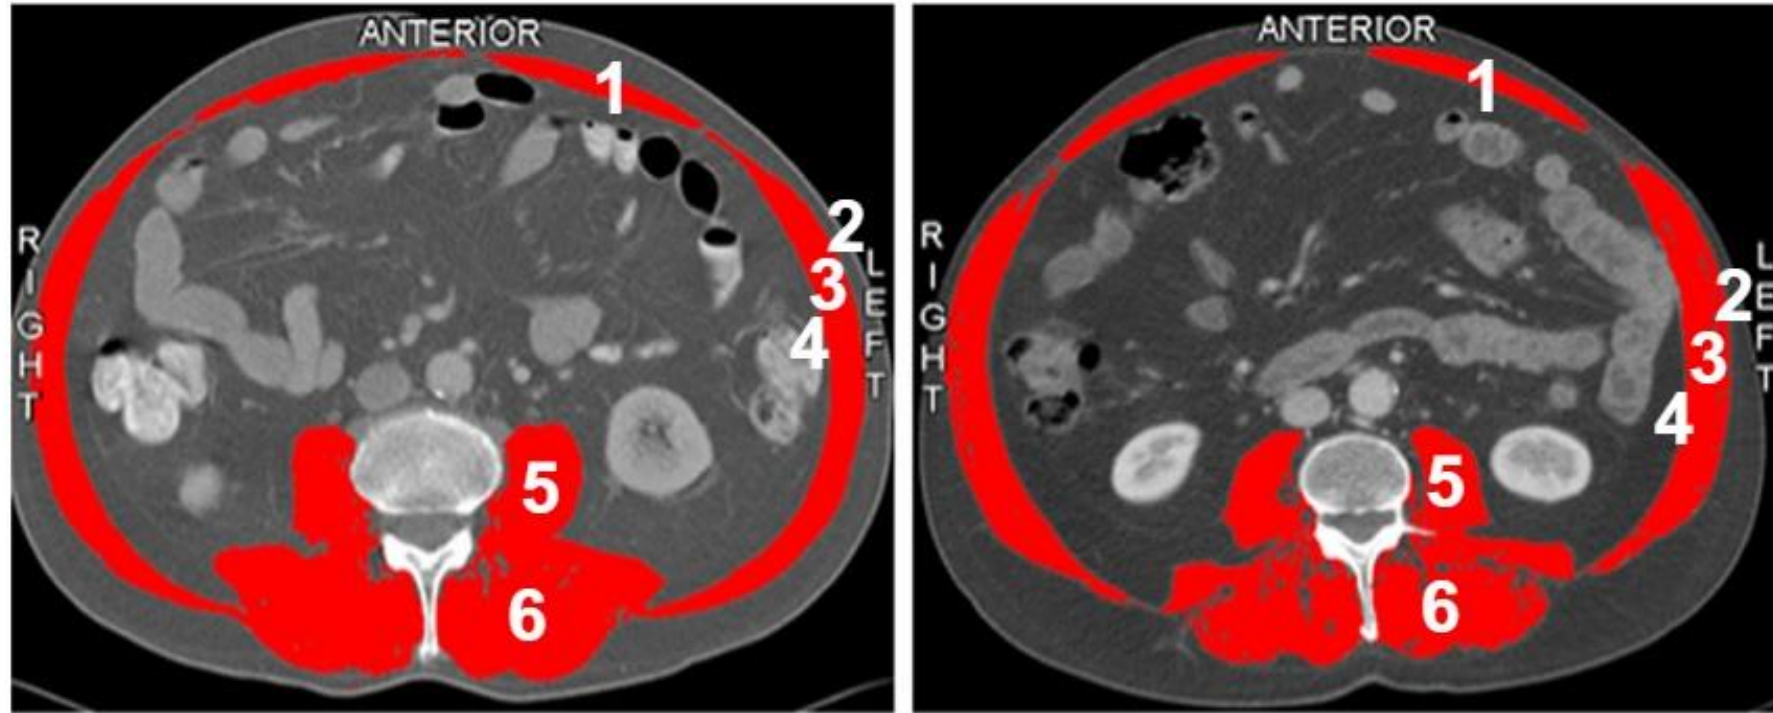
Computed tomography scans at the third lumbar vertebrae level of two male patients. *Right* Patient with a low skeletal muscle index (SMI, 56.8) (muscle mass) but a normal muscle attenuation index (MAI, 49.8) (muscle quality). *Right* Patient with a normal SMI
